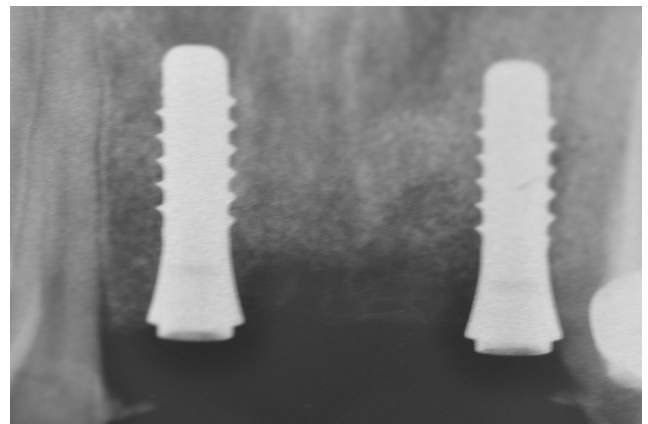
Intraoral radiograph of zirconia implants
